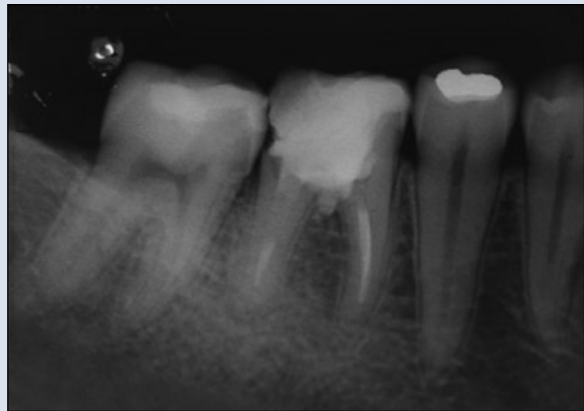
Case 2. Periapical image of tooth 46 showing inadvertent furcal perforation, caused by drilling during access preparation for root canal treatment.
